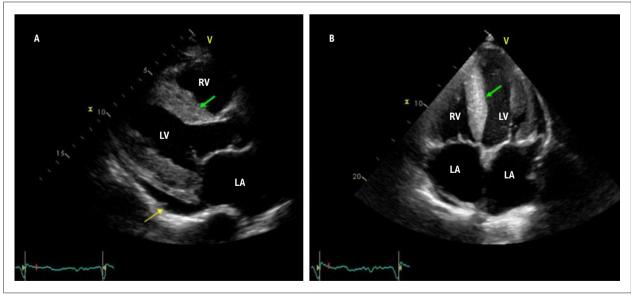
Classic echocardiographic presentation of cardiac amyloidosis. In A, the longitudinal parasternal projection shows a normal-sized left ventricle (LV) with increased wall thickness and a granular aspect in the interventricular septum (green arrow). There are also signs of left atrium (LA) enlargement and mild pericardial effusion (yellow arrow). In B, the apical projection shows large atria, normal-sized ventricles, and increased wall thickness, as well as a granular aspect in the interventricular septum (green arrow). The mitral and tricuspid valves are slightly thickened. LV: left ventricle; RV: right ventricle; LA: left atrium. (Images from the authors' personal archive).
